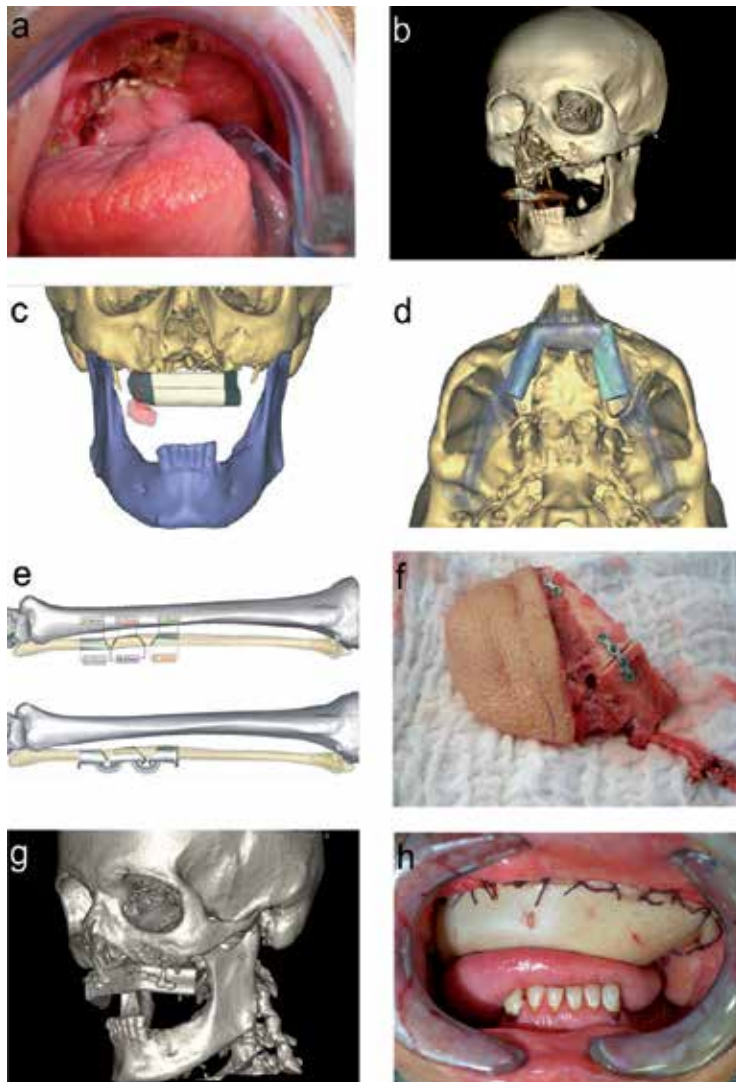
Case 5. (a) and (b) Extensive osteonecrosis and extensive bony destruction of the upper jaw. (c) and (d) Virtually restored native anatomy and virtually inset of fibula bone to imitate the natural maxillary arch. (e) Cutting guide for the three-segment fibula. (f) Prepared osteomyocutaneous fibula flap before inset. (g) and (h) Postoperative 3-D CT and total soft tissue covering of the former subtotal maxillary defect.
